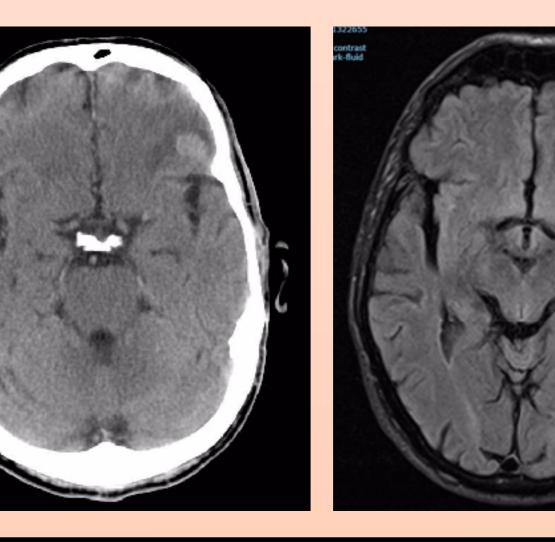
Tranverse sections of CT head (left) and MRI head with contrast (right) revealing left frontal lobe lesion.
